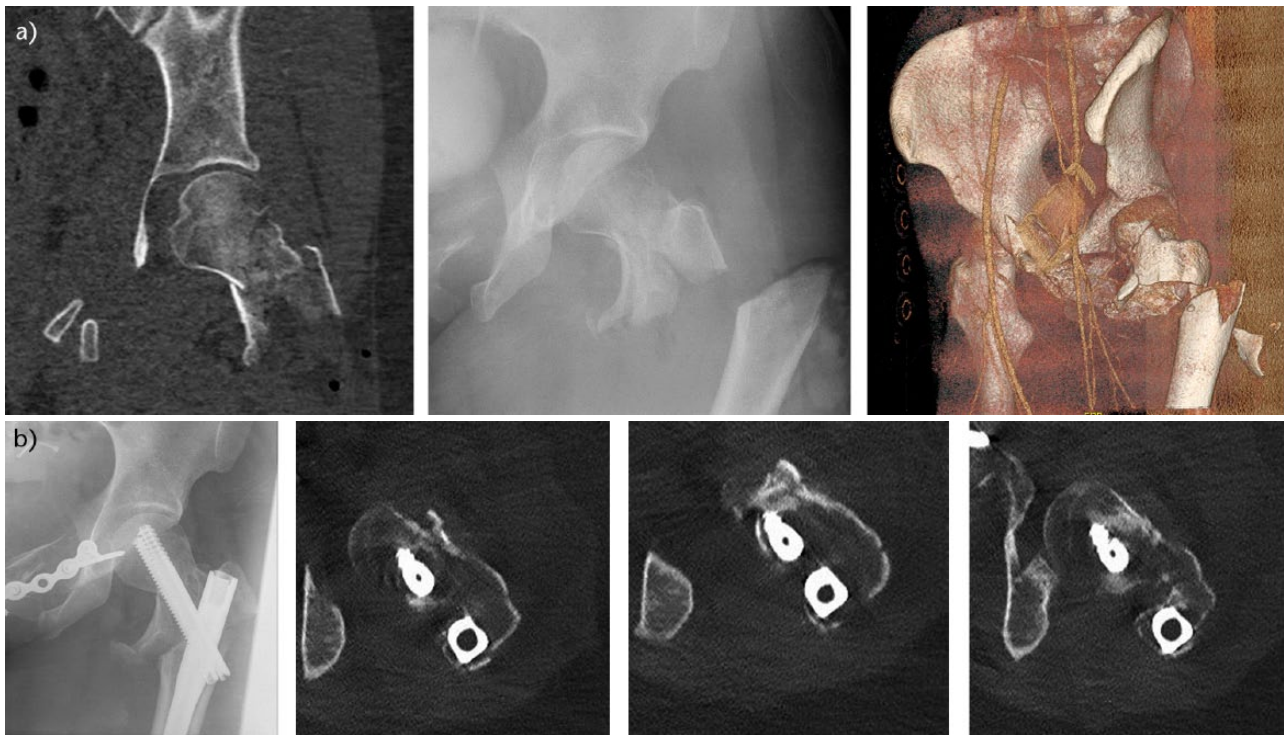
Images showing fixed compression in a young patient; a) segmental open high energy femoral fracture with wedge component in the neck and b) 12-week radiographs and CT slices demonstrating anatomical reduction of the neck and maintenance of reduction with the fixed compression.
